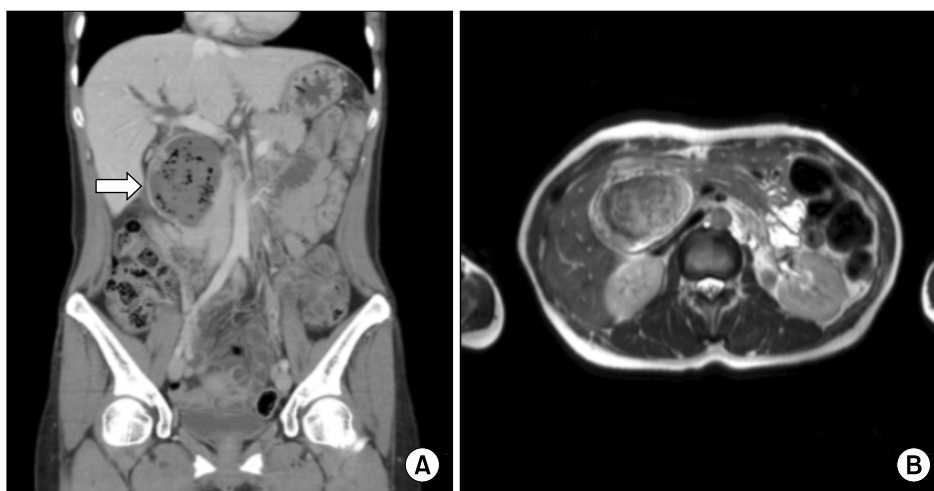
Imaging studies of the patient. (A) Patient's abdomino-pelvic computed tomogram shows dilatation of intrahepatic duct, pneumobilia, and a 6.8 cm×8.5 cm×5.0 cm-sized bezoar (arrow). (B) Magnetic resonance cholangiopancreatography also represents cystic dilatation of the extrahepatic bile duct.
